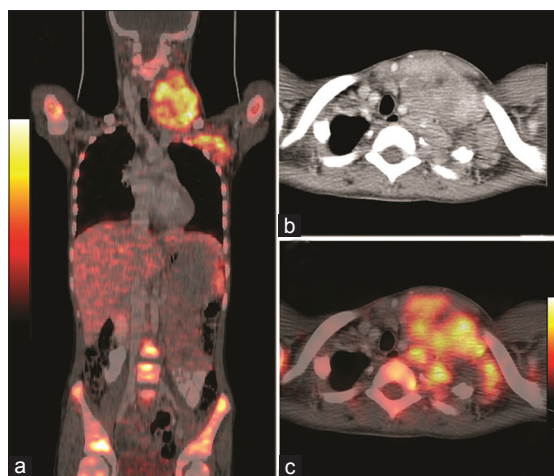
Pre-therapy Gallium-68 (Ga-68) DOTATATE positron emission tomography/computer tomography (PET/CT) coronal image (a) showing abnormal tracer uptake in an enhancing large soft tissue mass in the left neck (SUVmax 11.7), left cervical and axillary lymph nodes, and multiple bones. Transaxial CT (b) and fused positron emission tomography/computer tomography (PET/CT) (c) images show abnormal tracer uptake in a large enhancing soft-tissue mass on the left side of the neck (SUVmax 11.7)
